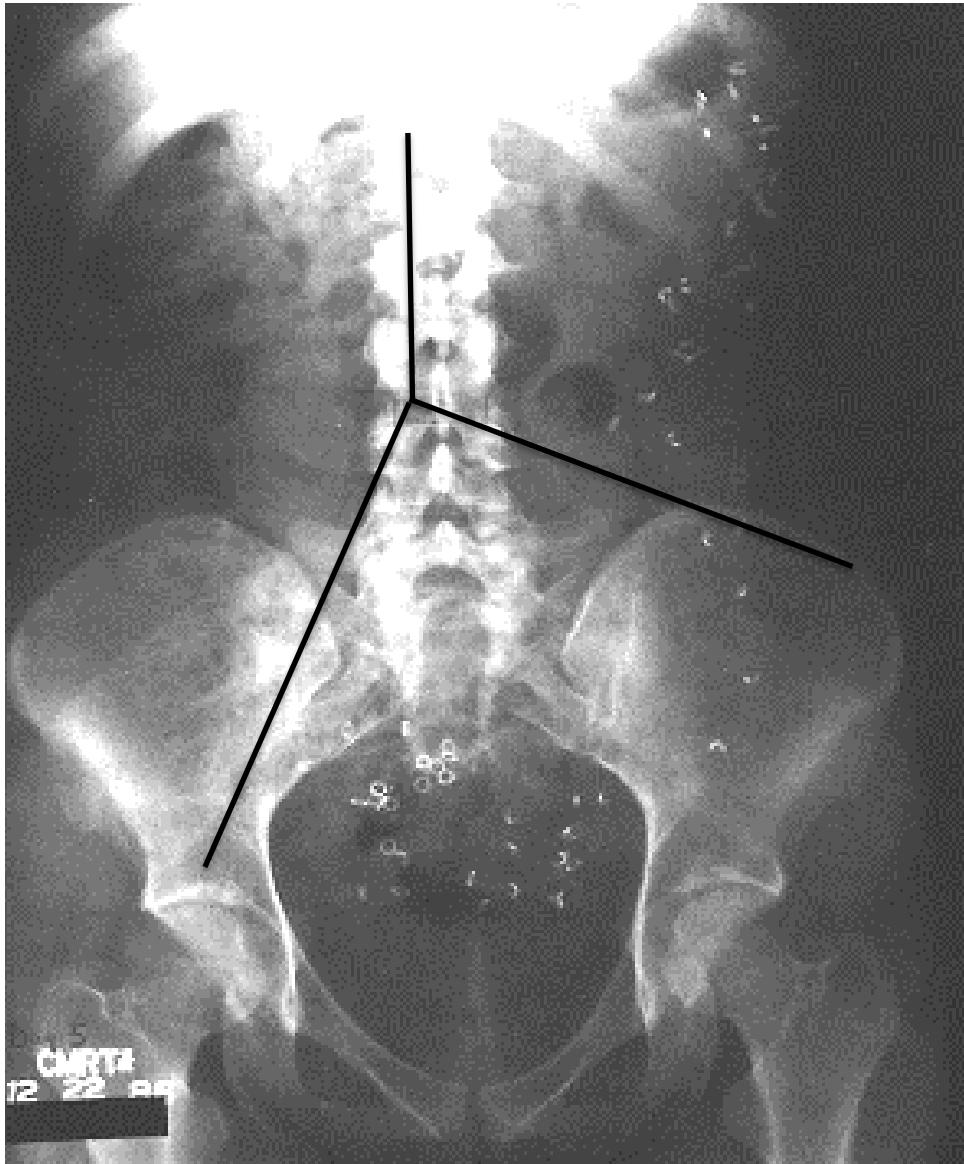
Radio-opaque marker study (ROM). An anterior abdominal x-ray 100 h following ingestion of radio-opaque markers (ring shape), which are retained mostly on the left side of the colon. Lines are usually drawn to divide the abdominal radiograph into three main regions based on known anatomical landmarks: right and left colon, and rectosigmoid area; this can help with marker localisation.
